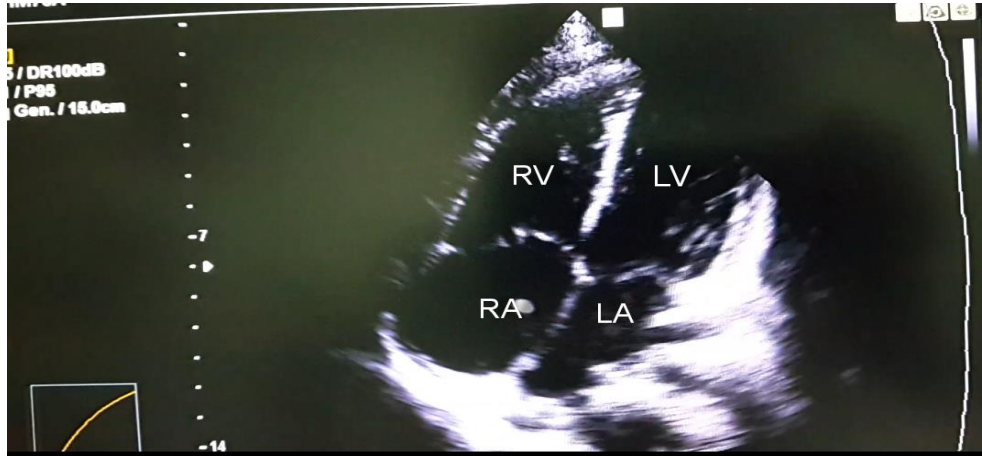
Echocardiographic frame taken after removal of hydatid cyst in 4 chamber
